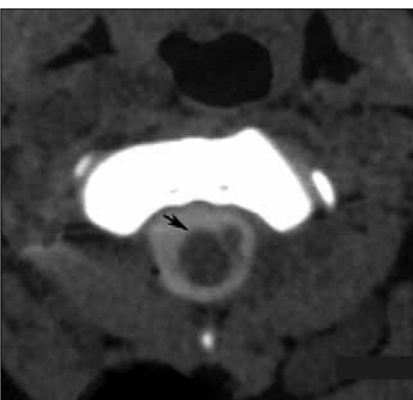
Cervical spinal cord axial CT revealed altered spinal cord morphology with associated surrounding neurofibromas at the level of C1-2.
